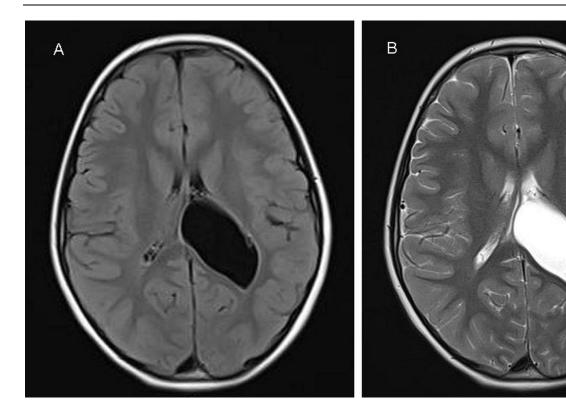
Brain magnetic resonance imaging. A) Axial FLAIR image: the intraventricular cyst shows the typical water-like loss of signal, confirming its cerebrospinal fluid content. B) Axial T2-weighted image: a thin-walled hyperintense cerebrospinal fluid-like cyst inside the left ventricle is seen.
